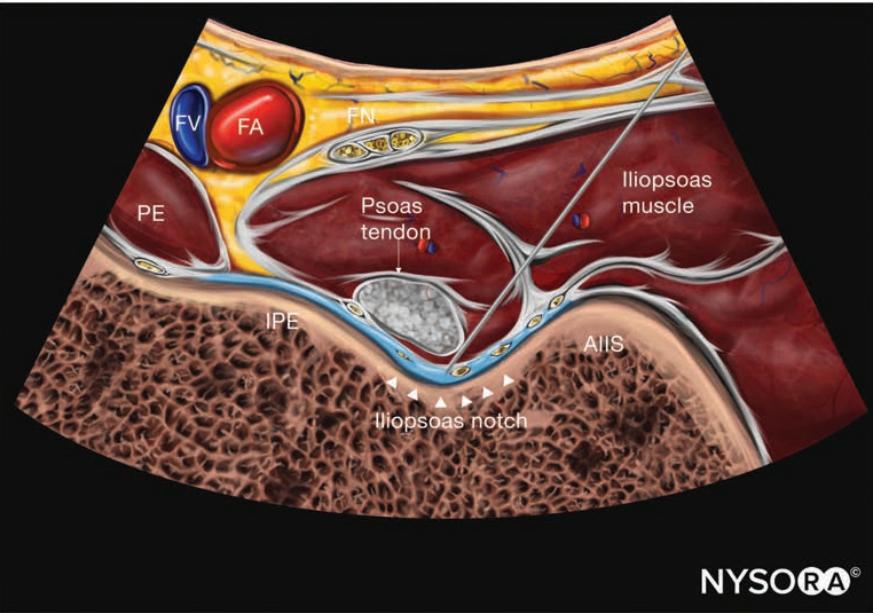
Hip block; reverse ultrasound anatomy with needle insertion in-plane. FV, femoral vein; FA, femoral artery; FN, femoral nerve; PE, pectenous muscle; IPE, iliopubic eminence; AIIS, anterior inferior iliac spine.
